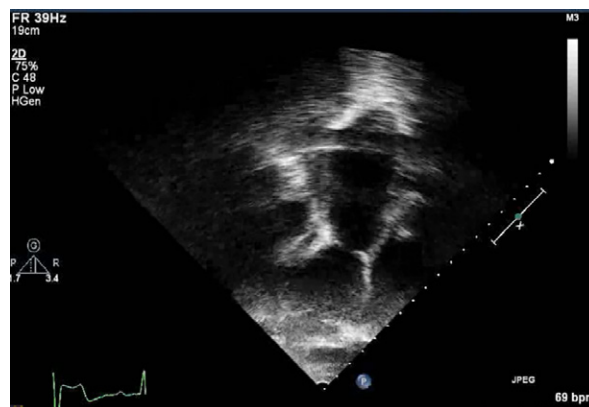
Two-dimensional transthoracic echocardiogram shows rudimentary pulmonary valve leaflets, a pulmonary annular diameter of 1.7 cm (Z score, -2.2), and a main pulmonary artery diameter of 5.13 cm (Z score, 9.37).
